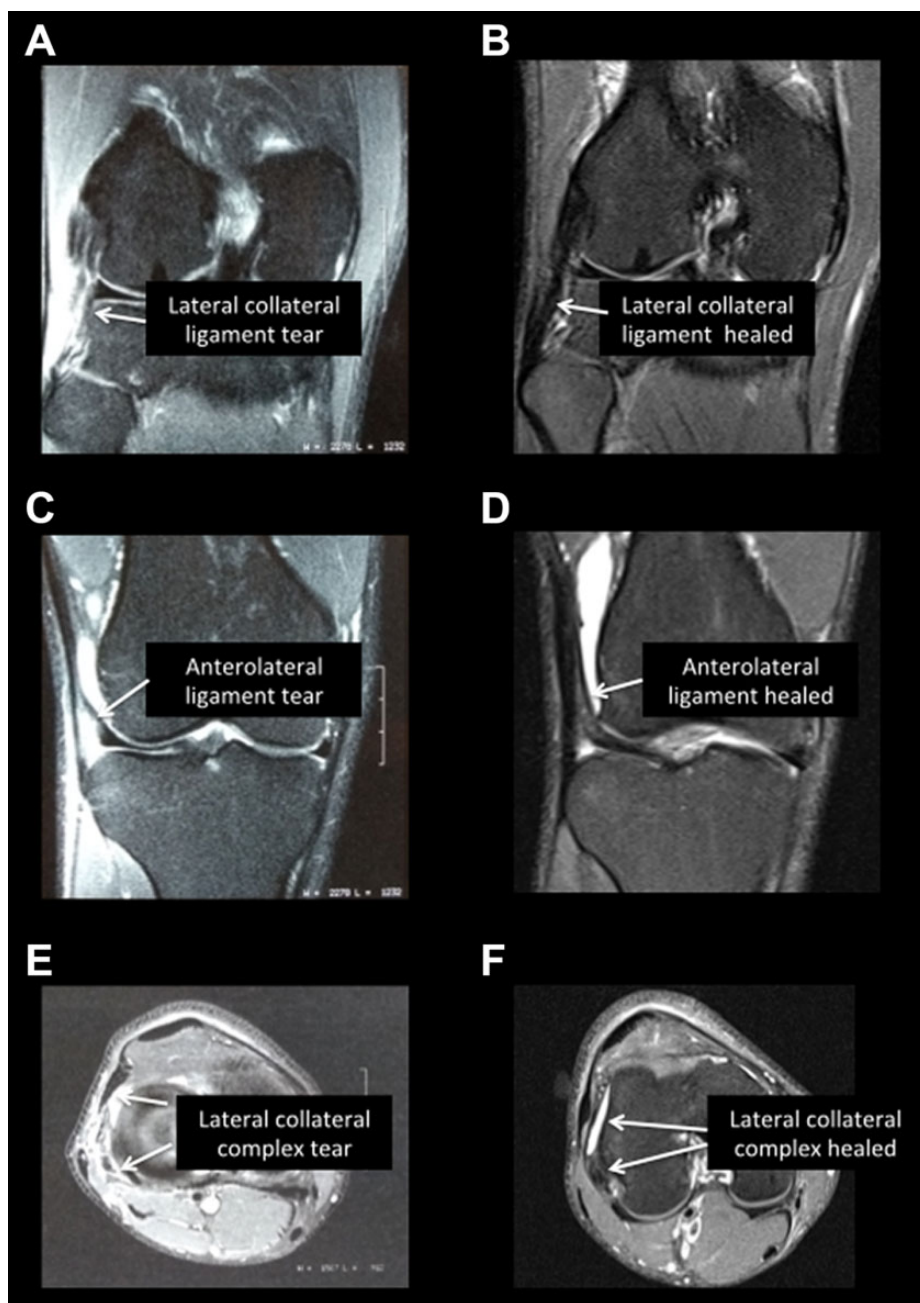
Magnetic resonance images of the partial lateral collateral ligament (LCL) and complete anterolateral ligament (ALL) immediately after injury and at 1 year of follow-up: (A, B) coronal T2-weighted images demonstrating the LCL; (C, D) coronal T2-weighted images demonstrating the ALL; (E, F) axial T2-weighted images demonstrating the LCL complex.
